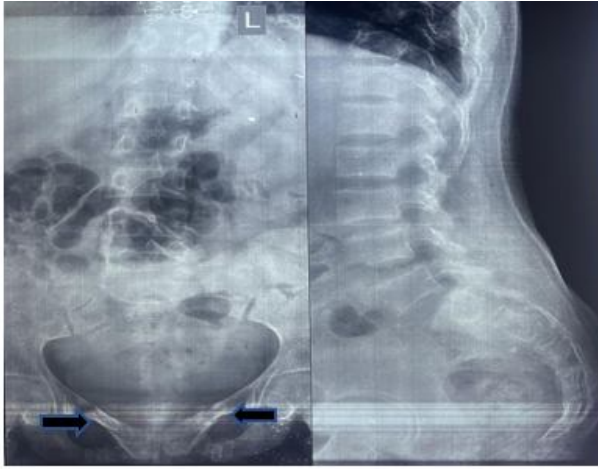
A X-ray LS spine AP and LAT
